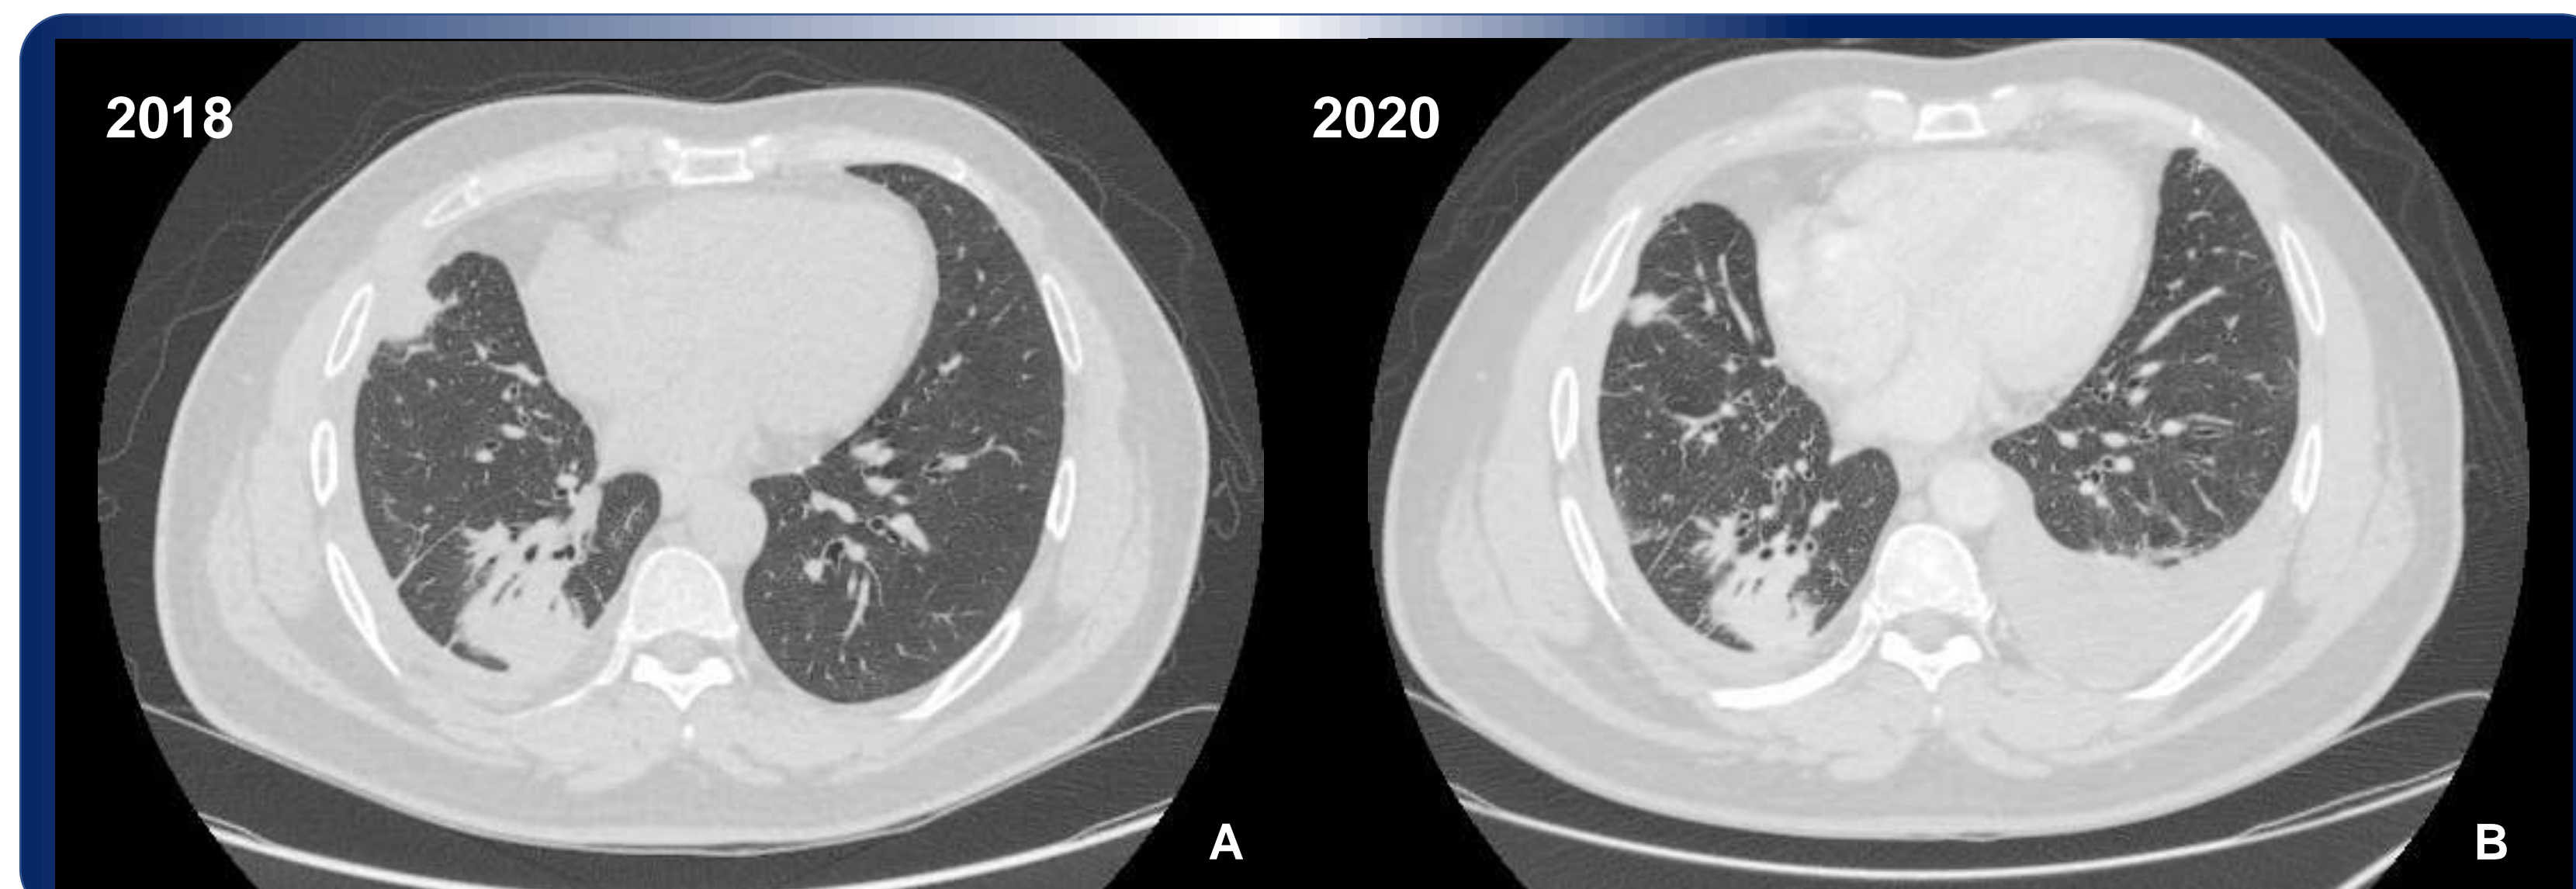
A. Chest CT showed consolidation and round atelectasis of right lower lobe with loculated right pleural effusion, B. Chest CT showed no changed of consolidation and round atelectasis of right lower lobe with new left pleural effusion.
